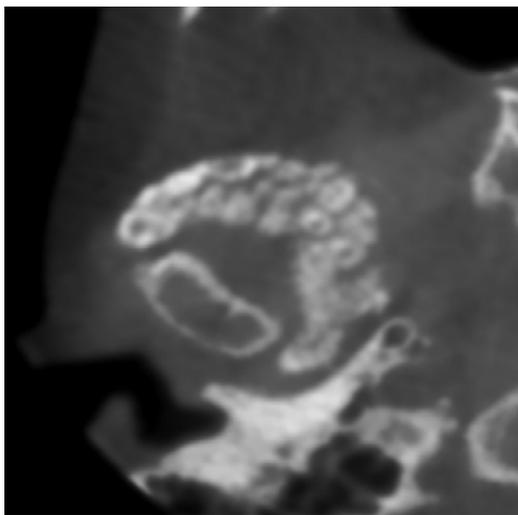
Cropped axial CBCT of the right TMJ with primary synovial chondromatosis shows multiple well-defined calcified structures with low density internal structures organized in the location of the anterior recess of the superior joint compartment (inferior to the crest of the eminence) (Courtesy, M. Noujeim DDS MS).
